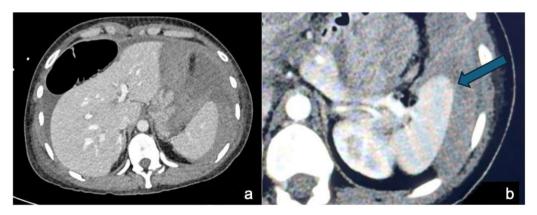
a) CT scan showing hemoperitoneum, b) CT in the arterial phase, showing the ST site (blue arrow).
